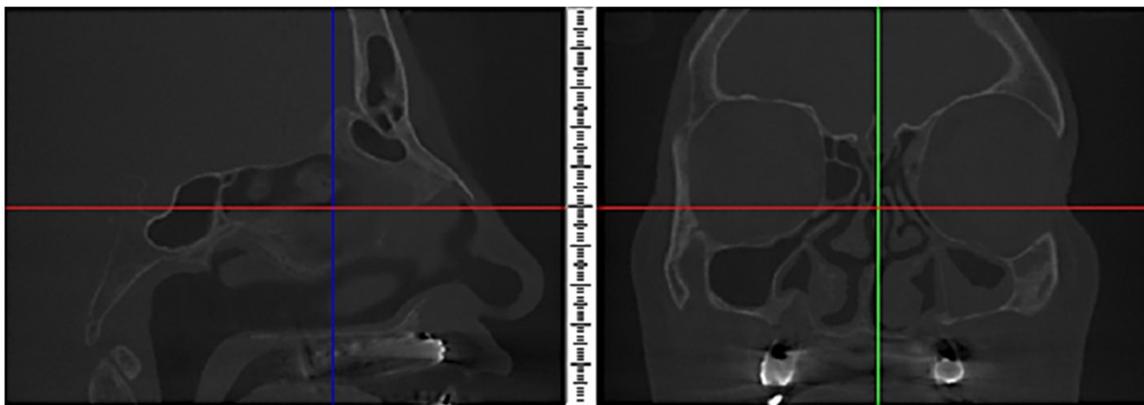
A new CBCT was performed. Coronal section shows nasal meatus inferior free from the implant.
